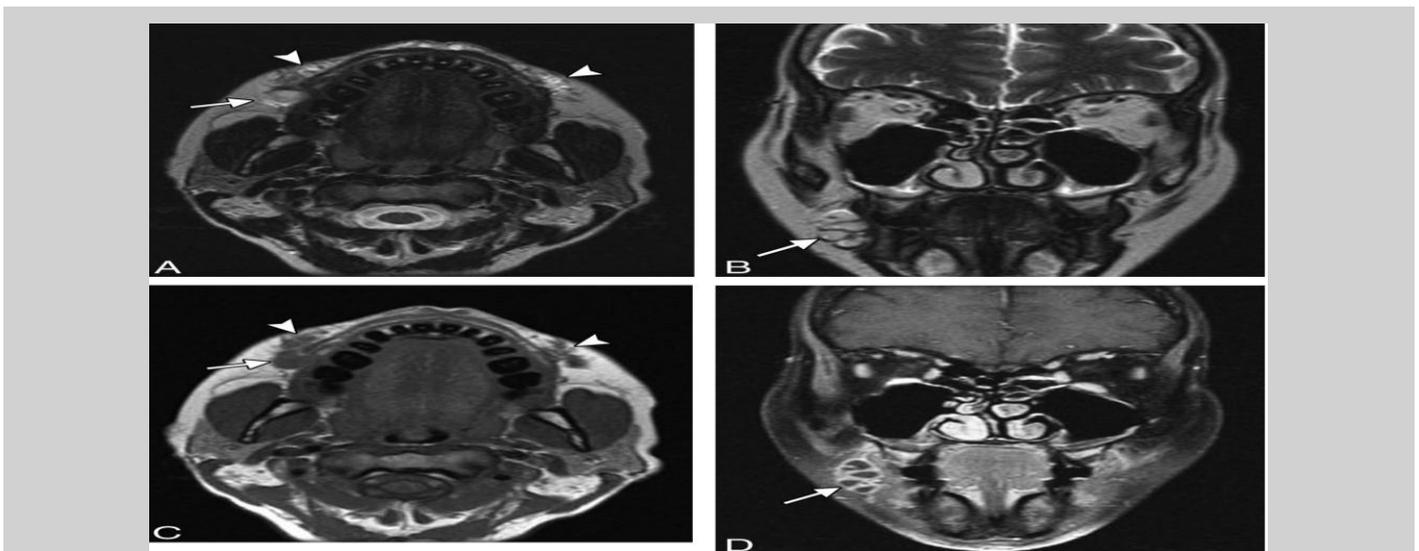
Abscess. Axial (A) and coronal (B) T2-weighted MR images, axial T1 (C), and coronal post-contrast fat-suppressed T1 (D) images demonstrate hyaluronic acid deposits within the bilateral oral cavity.
